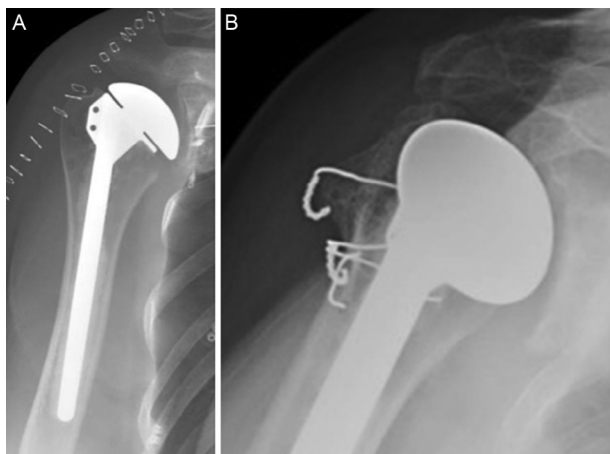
Anteroposterior radiographs demonstrate (A) adequate quality and (B) inadequate quality images for inclusion in the study.
